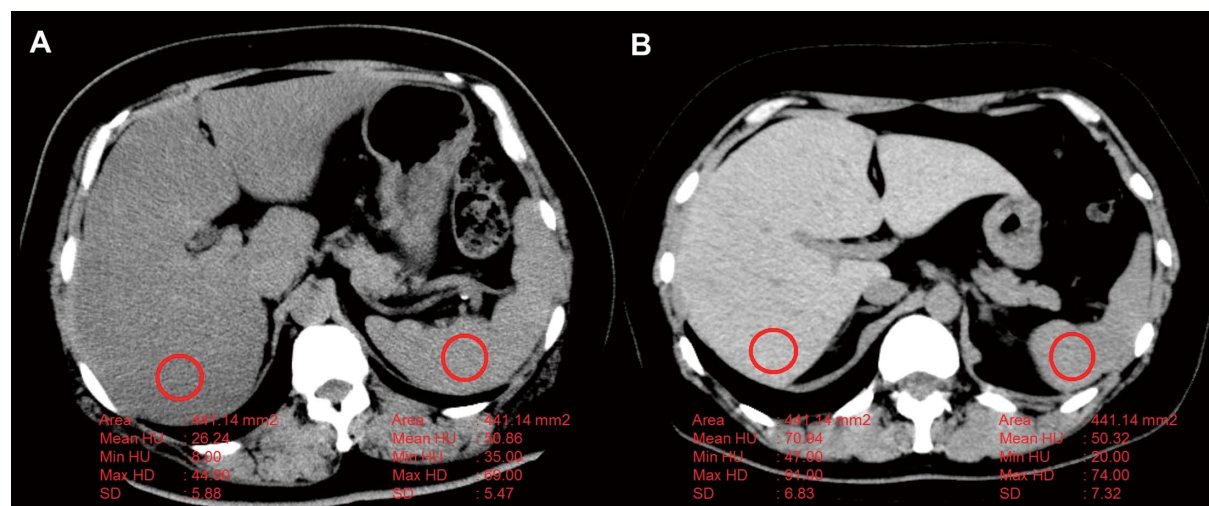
Definition of fatty liver. Non-contrast computed tomography (CT) images in patients with (A) and without (B) fatty liver. Unenhanced CT in patients with fatty liver shows diffuse fat accumulation in the liver. Liver attenuation (26 HU) minus spleen attenuation (51 HU) equals -25 HU. Fatty liver was considered to be present when the liver HU is less than the spleen HU minus 10. HU, Hounsfield units.
